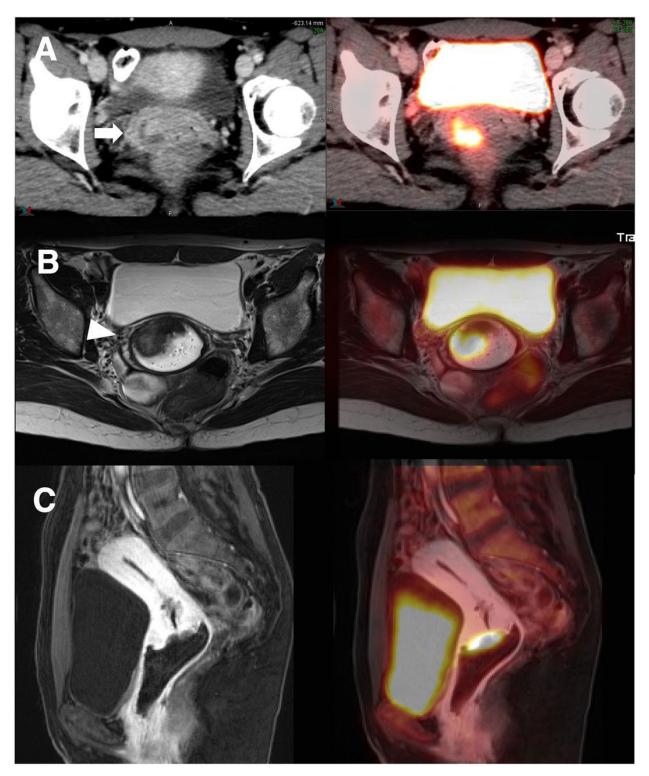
Poorly differentiated squamous cell carcinoma of cervix showing CT (A; left) and PET/CT (A; right) with corresponding unenhanced T2-weighted turbo spin-echo (B; left) and T2-weighted turbo spin-echo PET/MRI (B; right). Contrast enhanced sagittal MRI T1-weighted Dixon-visual background extractor) (C; left) and PET/MRI (C; right) are also shown. Reprinted with permission (*32*).
